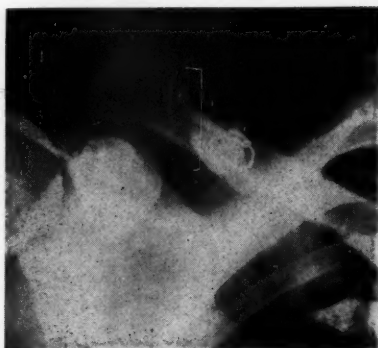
X-ray taken after removal of pin at eight weeks.
